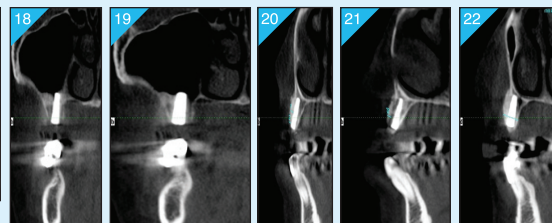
Four month post-operative sagittal view of 3D CBCT.
